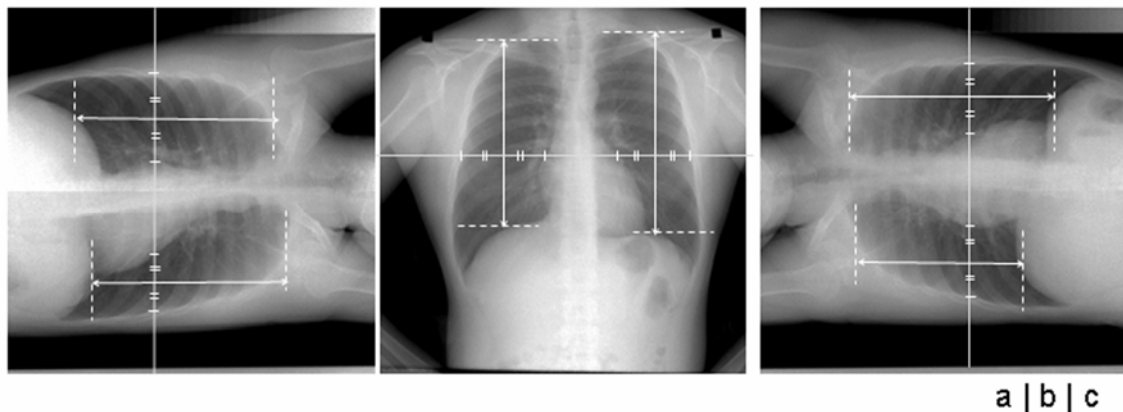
Dynamic chest radiographs obtained by our FPD system
